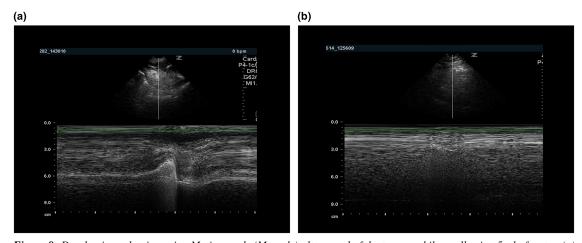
Dysphagia evaluation using Motion mode (M-mode) ultrasound of the tongue while swallowing 5 ml of water. (a) Healthy control showing clearly defined phases of tongue movement; (b) Young adult male with Duchenne muscular dystrophy showing minimal tongue movement due to severe weakness.
